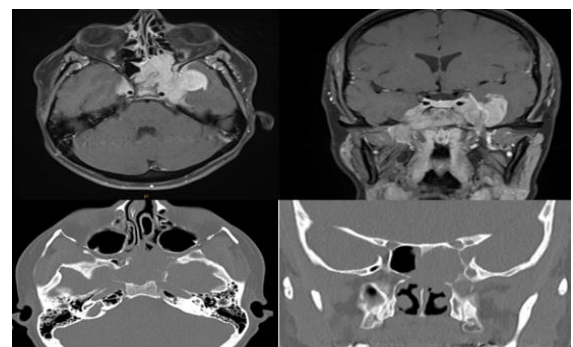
Top images demonstrate T1 post Gad axial and coronal MRI through the level of the sphenoid sinus and middle cranial fossa. The contrast enhancing lesion can be seen invading the cavernous sinuses bilaterally, the middle cranial fossa on the left with associated vasogenic oedema as well as filling the sphenoid sinus. Bottom images demonstrate a bone window CT with axial and coronal slices through the same areas as above showing local bony destruction concerning for an invasive process.
